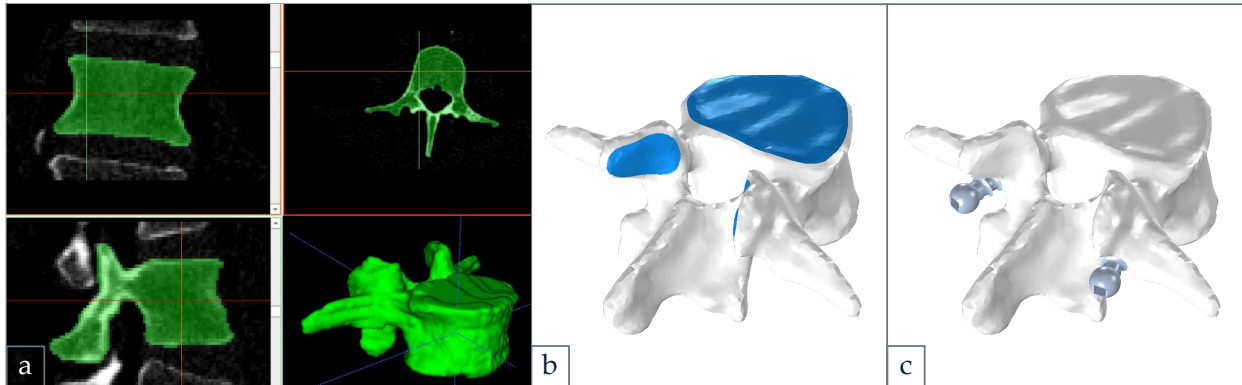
Procedure for geometry creation: segmentation from CT images (a); smoothing and manual partitioning of articular facets, top and bottom endplates (b); virtual implantation of screws and assembly creation (c).
